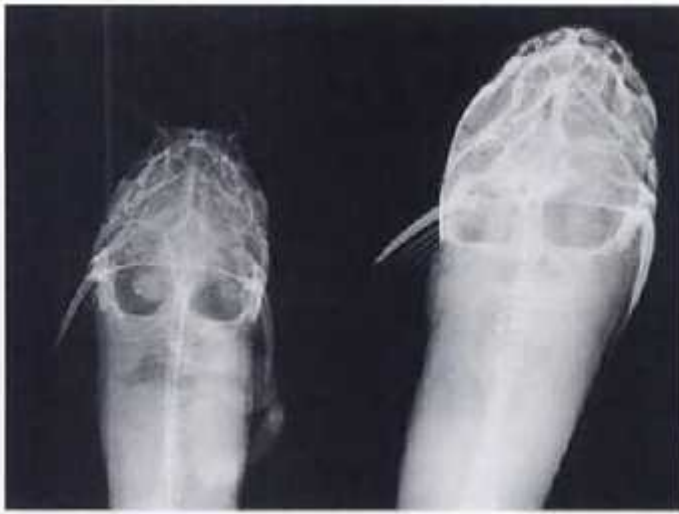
X-ray photograph of normal (left) and ascorbate- deficient Asian catfish (crackhead) showing distinct loss of radio opacity (Picture courtesy: Ronald J. Robert, Nutritional Pathology)
